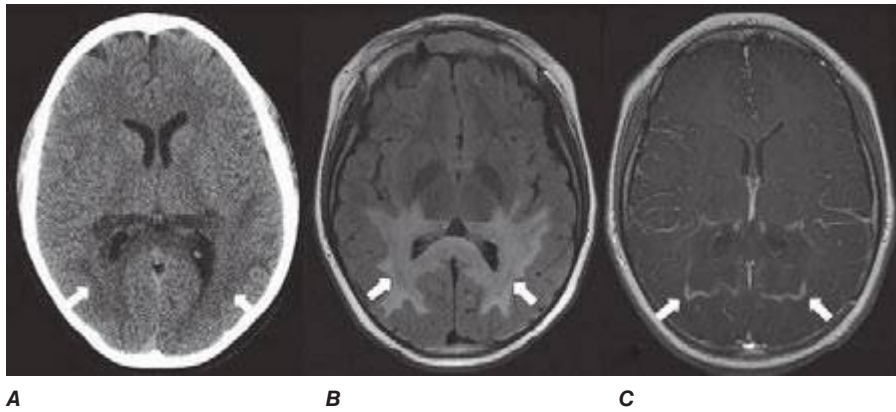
56 X-linked adrenoleukodystrophy (Chap. 459). Axial unenhanced CT (A) demonstrates areas of attenuation involving the posterior white matter bilaterally (*arrows*). Axial T2 FLAIR MRI (B) displays increased T2 signal consistent with edema (*arrows*). Axial T1-weighted image postgadolinium (C) shows peripheral enhancement of the parietal lesions bilaterally (*arrows*). These findings are typical of adrenoleukodystrophy.
